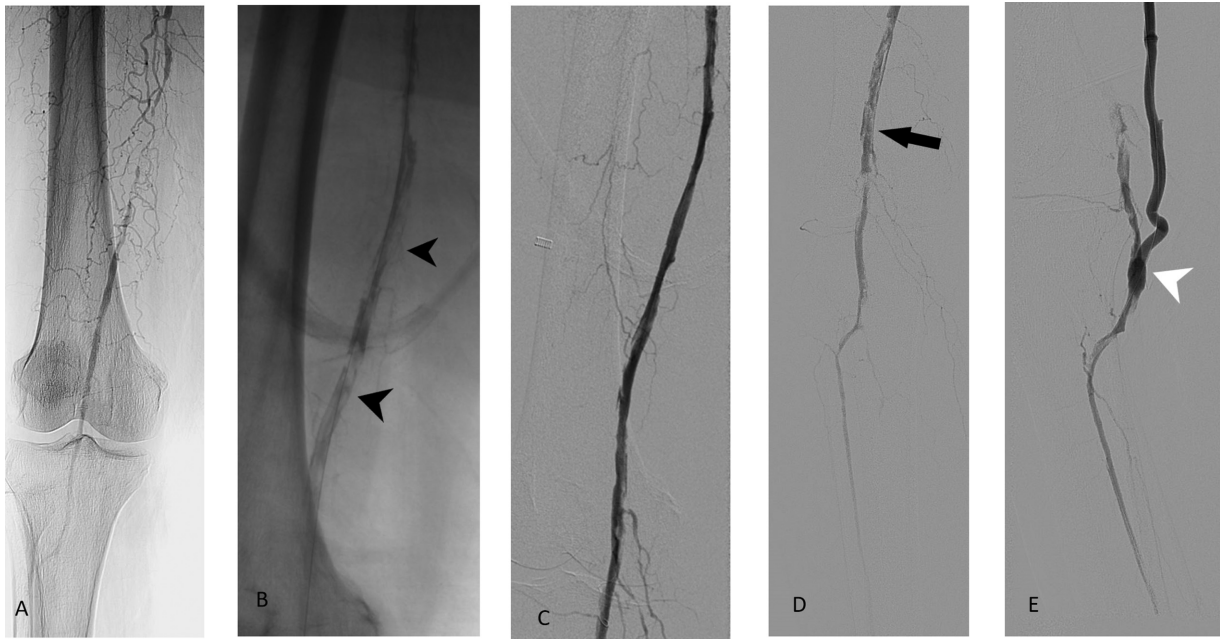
(A) Acute in situ thrombosis of superficial femoral artery occlusion in a 65-year-old female patient with critical limb ischemia. After crossing the lesion subintimal angioplasty was done. Postangioplasty angiogram showed dissections and multiple filling defects all along the lumen (arrowhead in B). She underwent catheter-directed thrombolysis (CDT) with multiple side hole catheter for approximately 6 hours followed by balloon angioplasty resulted in a good opening of the lumen (C). Doppler after 12 hours showed re-occlusion of lumen with no color flow with repeat angiogram showing multiple filling defects in lumen (D). She underwent repeat CDT for next 24 hours and a repeat angiogram showed not much luminal gain. With the rest pain not improving, she underwent femoropopliteal bypass in the hybrid theater with post bypass angiogram (E) showing good distal flow.
